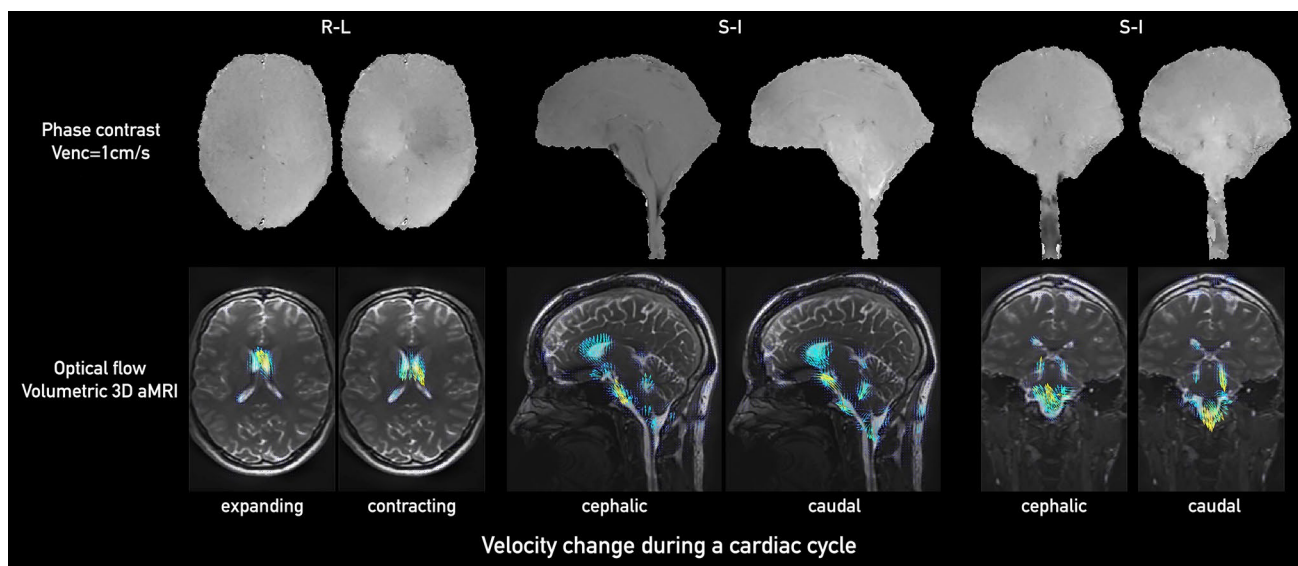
Comparison between PC-MRI (top) and optical flow maps calculated from volumetric 3D aMRI (bottom) for sagittal (left two panels), coronal (middle two panels), and axial (right two panels) planes. Here, we show the pair of 12th and 19th phases of a cardiac cycle (the same total number of 20 phases collected for each of the PC-MRI and volumetric 3D aMRI methods). The optical flow maps capture the relative brain tissue deformation over time and the physical change in shape of the ventricles by the relative movement of the surrounding tissues
